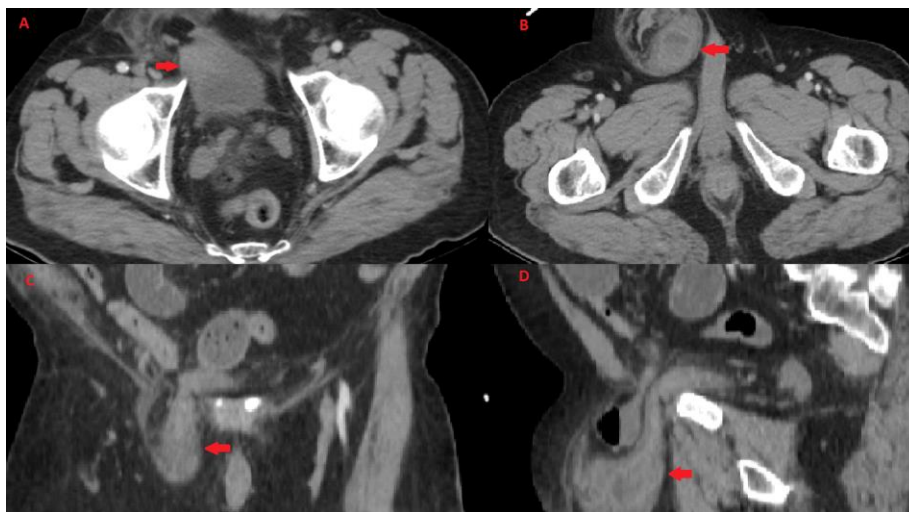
Preoperative computed tomography sections. 1A: Bladder herniated into the inguinal canal in transverse view. 1B: Bladder and bowel loops herniated into the inguinal canal in computed tomography transverse view. 1C: Bladder herniated into the inguinal canal in computed tomography coronal view. 1D: Bladder and bowel loops herniated into the inguinal canal in sagittal view.
